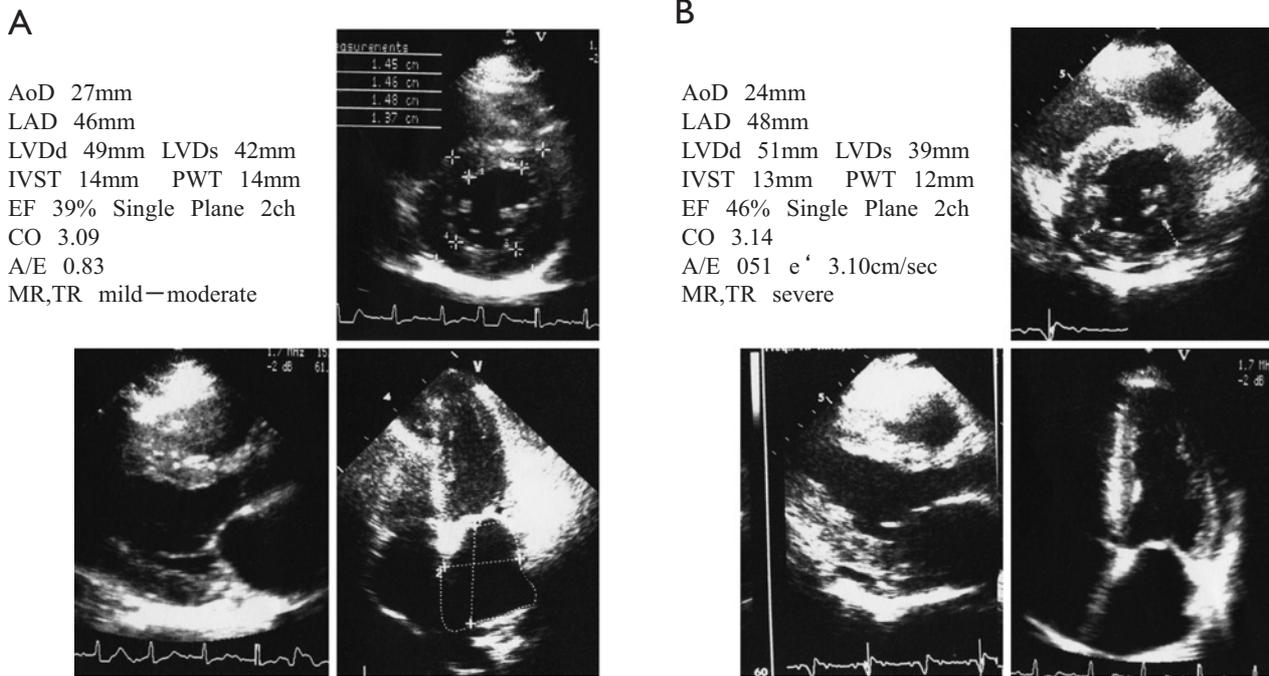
Transthoracic echocardiogram at the first visit (A) and 7 years later (B). Left ventricular hypertrophy was observed at the first visit and later, and a characteristic “granular sparkling” appearance of the ventricular wall became evident later.
